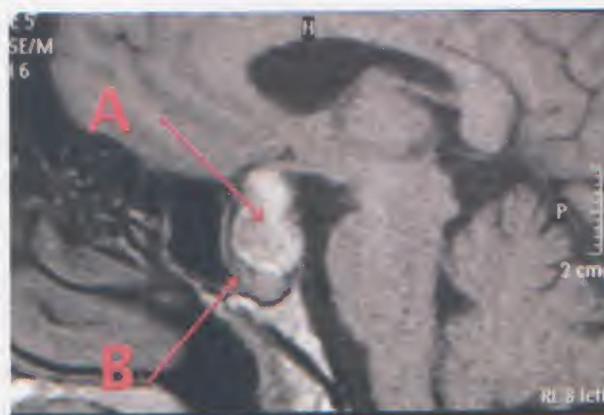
Sagittal MRI T1 weighted image of the brain without contrast showing a pituitary adenoma with pituitary apoplexy –pituitary hemorrhage- (A). The hemorrhage appears hyper-intense (white) and compresses the pituitary tissue which appears as a grey peripheral rim (B)
